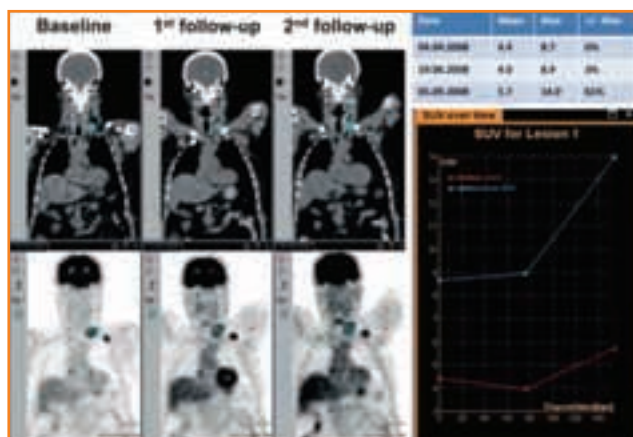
Computer-assisted semiquantitative analysis of 18F-FDG PET/CT showing automatic lesion tracking during a baseline scan and two follow-up scans. (Reproduced from Apostolova I, et al.¹⁷ © Schattauer 2011, with permission).
